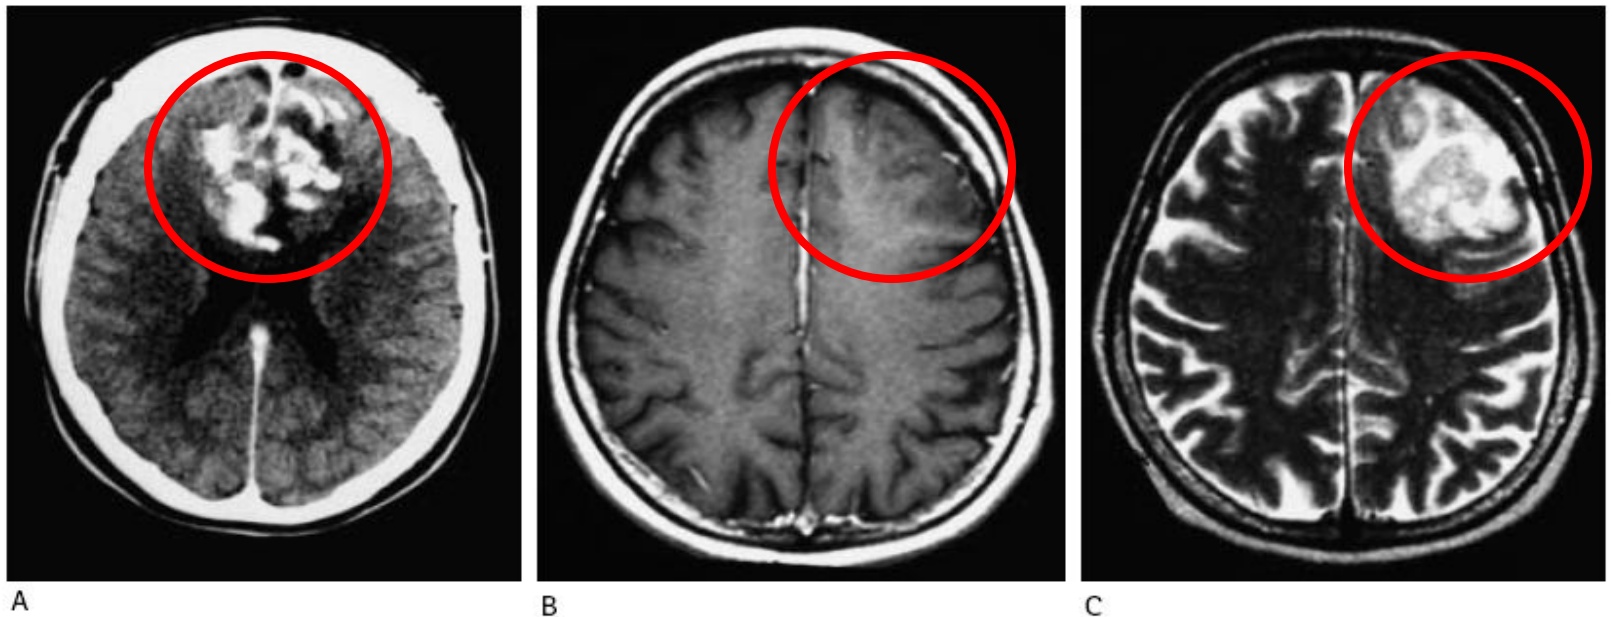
Oligodendroglioma. (A) Enhanced postoperative CT scan showing showing large residual tumor involving the corpus callosum and both frontal lobes with areas of heavy calcification. (B) Axial MRI with gadolinium showing a non-enhancing left frontal oligodendroglioma which is much better seen on (C) axial T<sub>2</sub>-weighted image.
